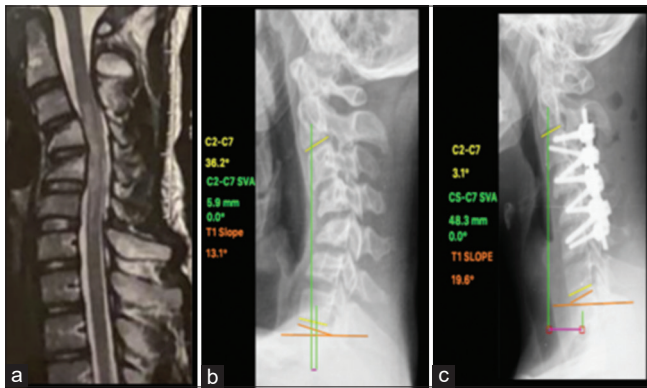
Male, 16-year-old. Motorcycle accident. AO Spine: C4-C5 B2 (C4:A1; C5:A1; F4; N3)/C5-C6 B2 (N3). Frankel C. 30 days of evolution. Injury by a flexion-distraction mechanism at C4-C5. MRI is demonstrating spinal cord contusion and posterior ligament injury (a), Radiograph showing regional kyphosis and C4-C5 facet subluxation (b), C3-C6 bilateral pedicle instrumentation was performed with correction of sagittal alignment (c)
